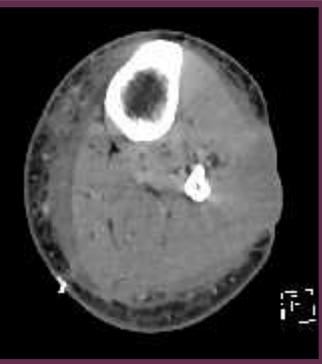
CT scan of the left leg following 1st debridement and fasciotomy of the anterior and lateral compartments.
